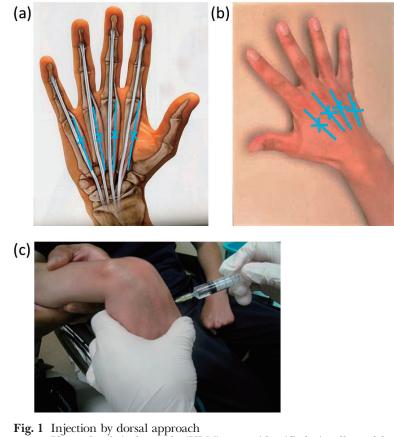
Injection by dorsal approach Upper lumbrical muscle (ULM)s were identified visually and by palpation without using electrical stimulation or sonography.
